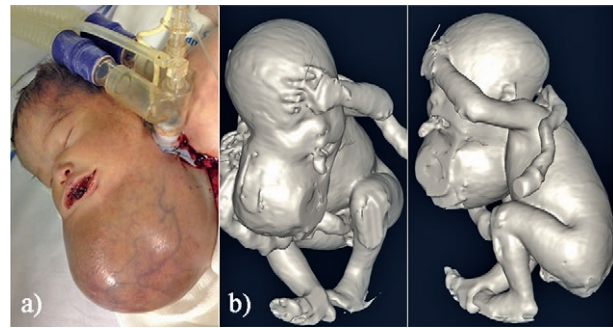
a) Neonate after tracheostomy; b) three-dimensional virtual reconstruction after magnetic resonance imaging showing cervical mass.
